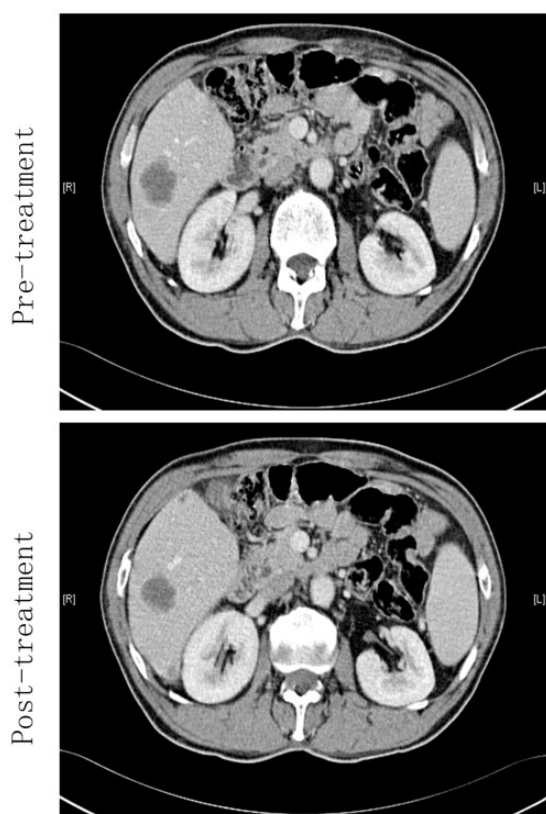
Clinical case number 1. CT scan before and after 20-kHz ultrasound with chemotherapy for the tumors.
